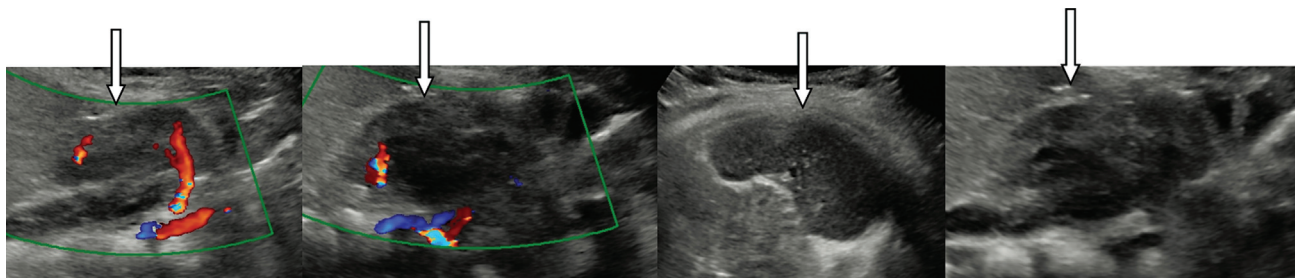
Postnatal ultrasound of the baby confirming lack of corticomedullary differentiation in both kidneys.
